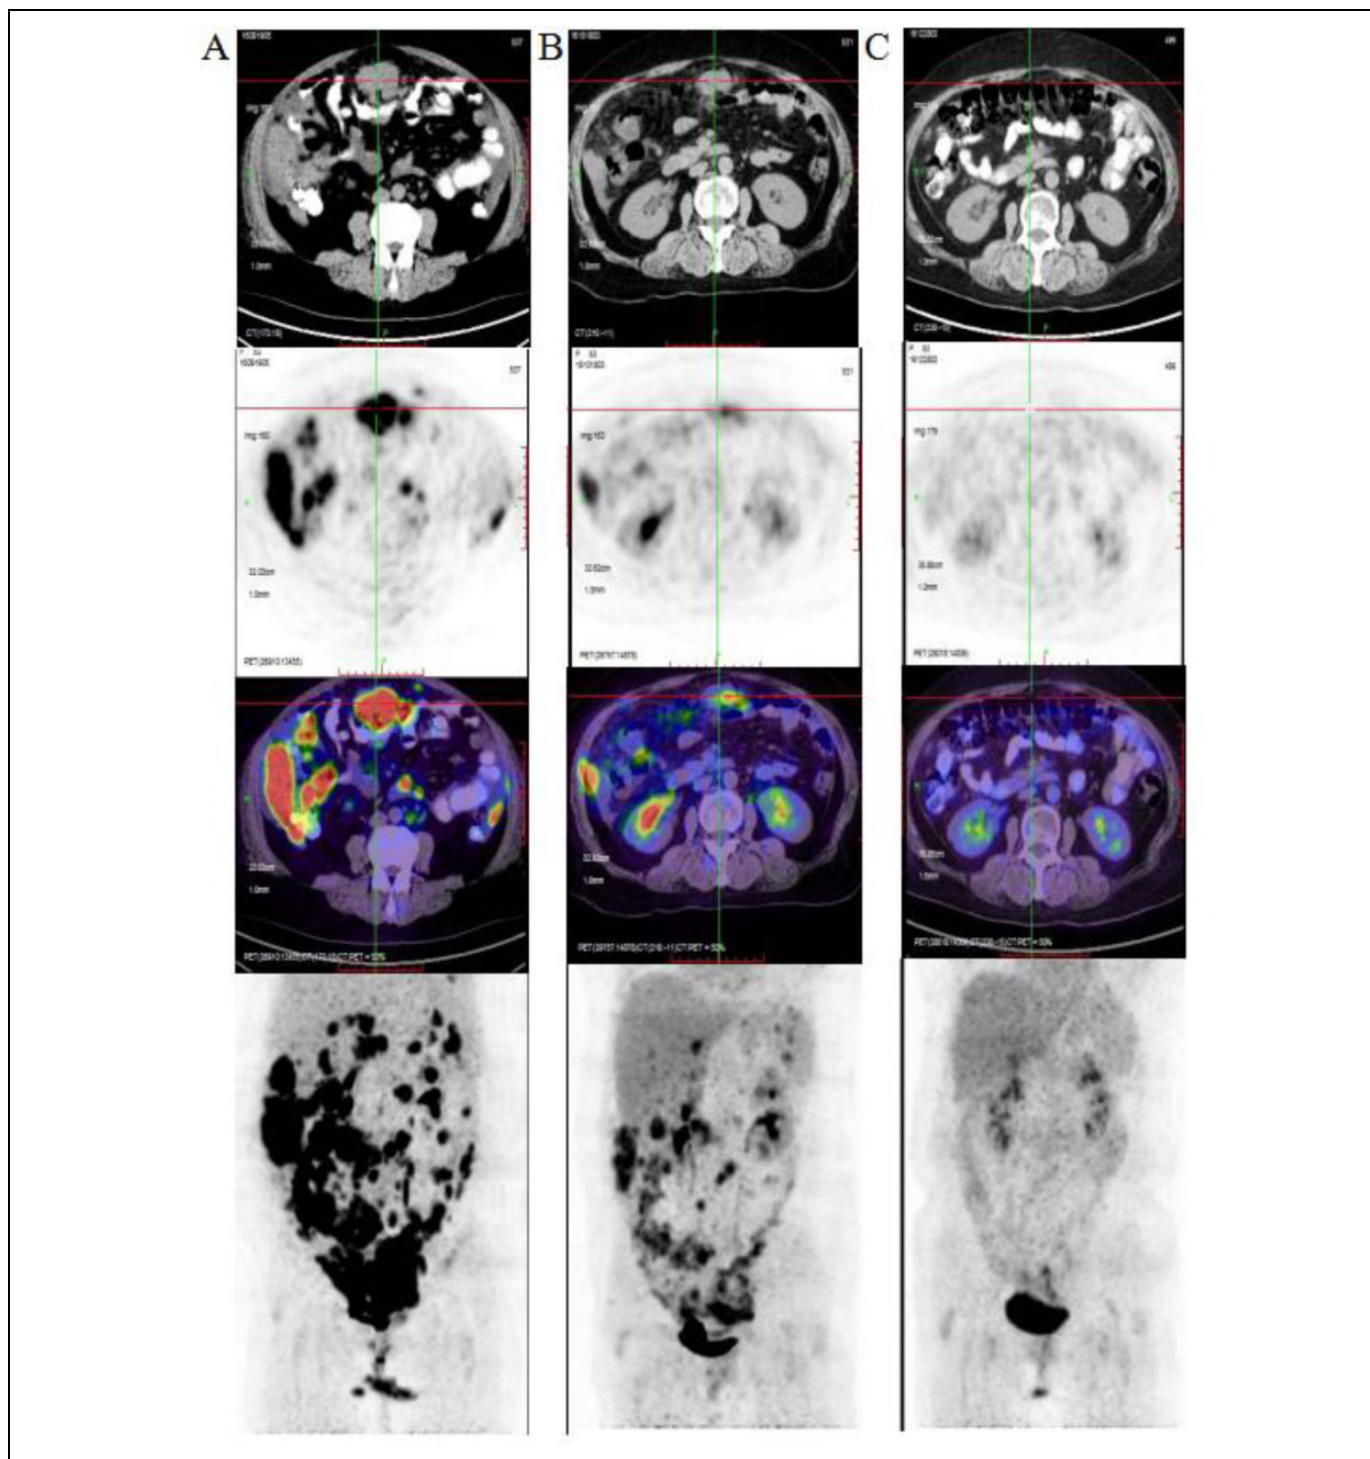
PET-CT scans of a 59-year-old female (A) prior to treatment, and following the (B) first and (C) second treatment. The results revealed that the metabolism of the lesions had disappeared. (Note: Part of Figure was cited from our previous study, Dang et al. 2018¹⁵).
